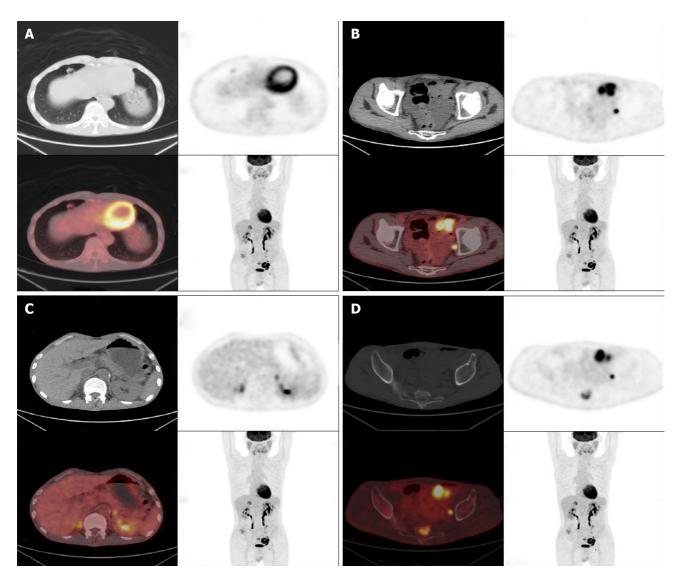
Positron emission computed tomography/ computed tomographic scan. A: A soft tissue nodule located in the right middle lobe of the lung, about 1.3 cm × 1.0 cm in size, with multiple burrs at the edges and abnormal concentration of tracer; B: Partial small intestinal wall thickness, and abnormal concentration of tracer; C: Bilateral nodular hyperplasia of the adrenal glands, and abnormal concentration of tracer, especially on the right; D: The sacral bone with uneven density, and abnormal concentration of tracer.
